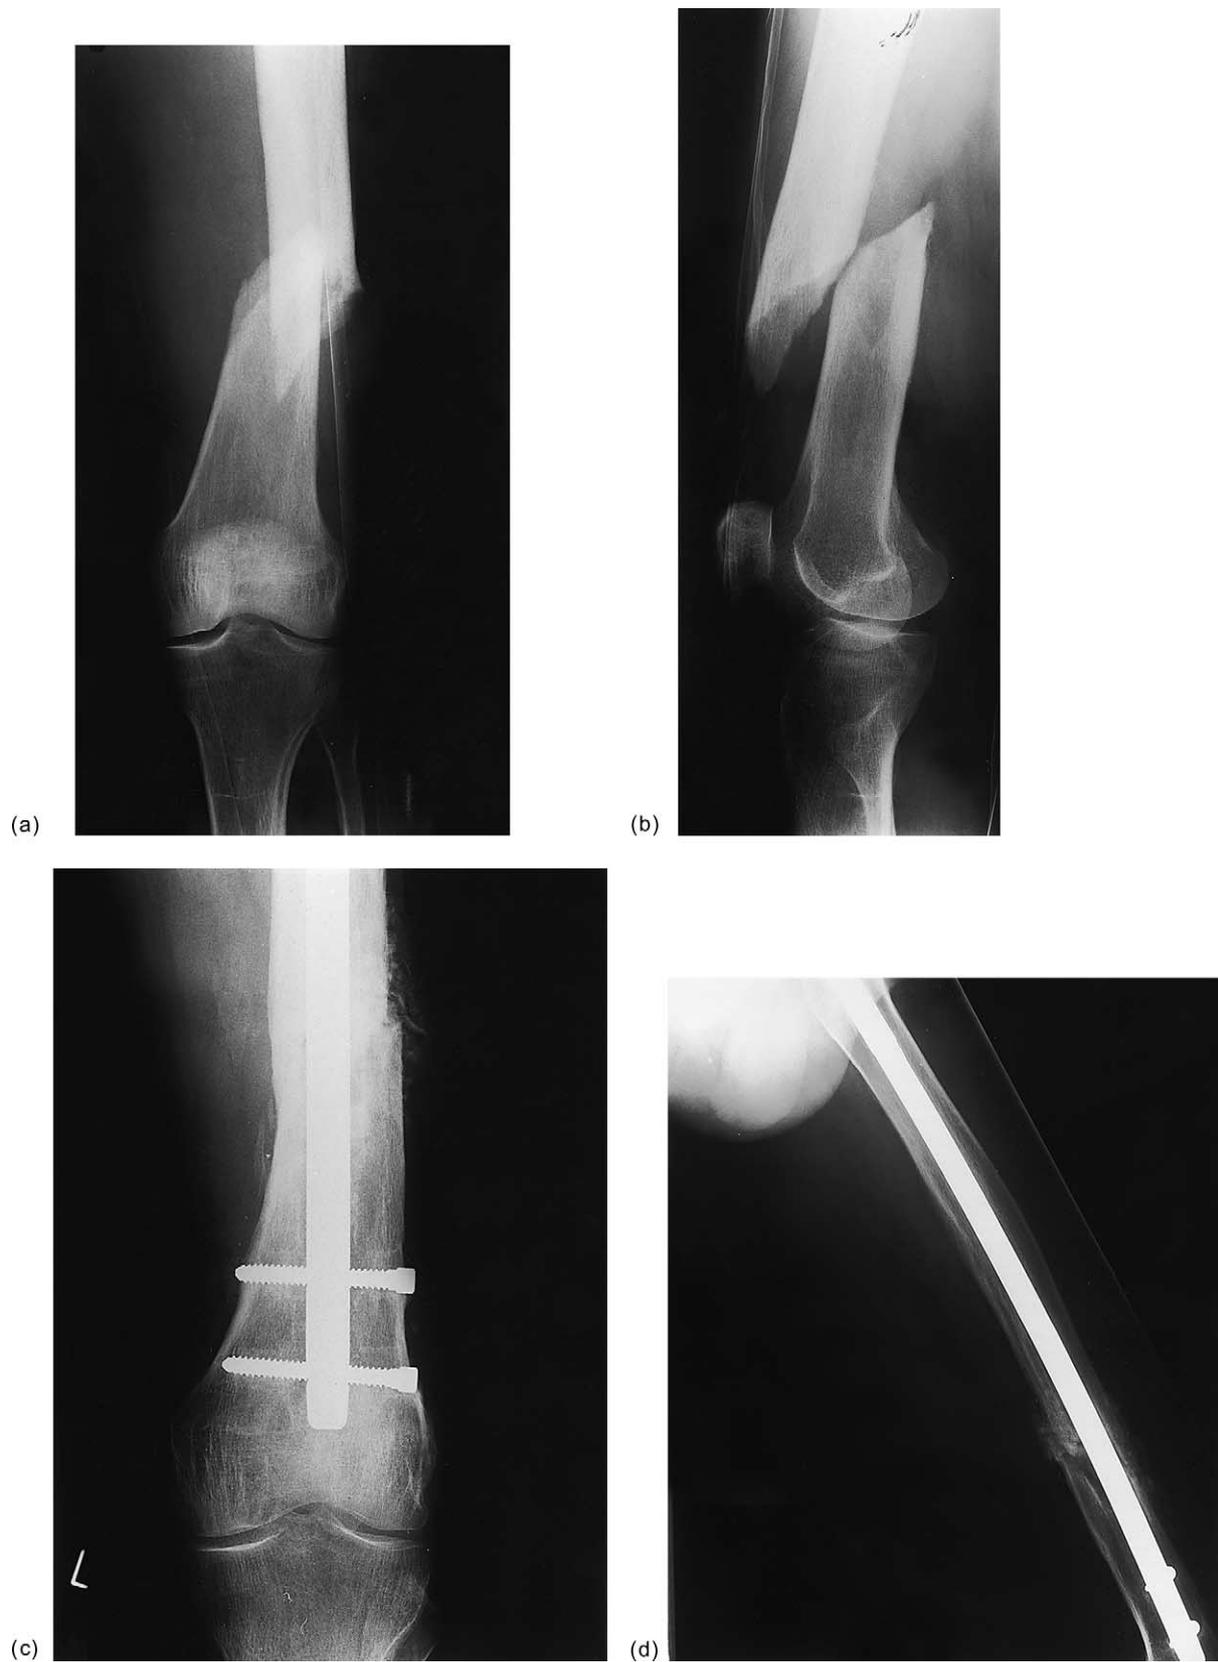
A 61-year-old male who sustained a left femoral shaft fracture. Anteroposterior and lateral radiographs of a fractured left femur (a and b). Anteroposterior and lateral radiographs of infected non-union left femur following exchange nailing (c and d). Anteroposterior and lateral radiographs after application Ilizarov frame (e and f). Anteroposterior and lateral radiographs of united left femoral fracture 4 years following original fracture (g and h).
